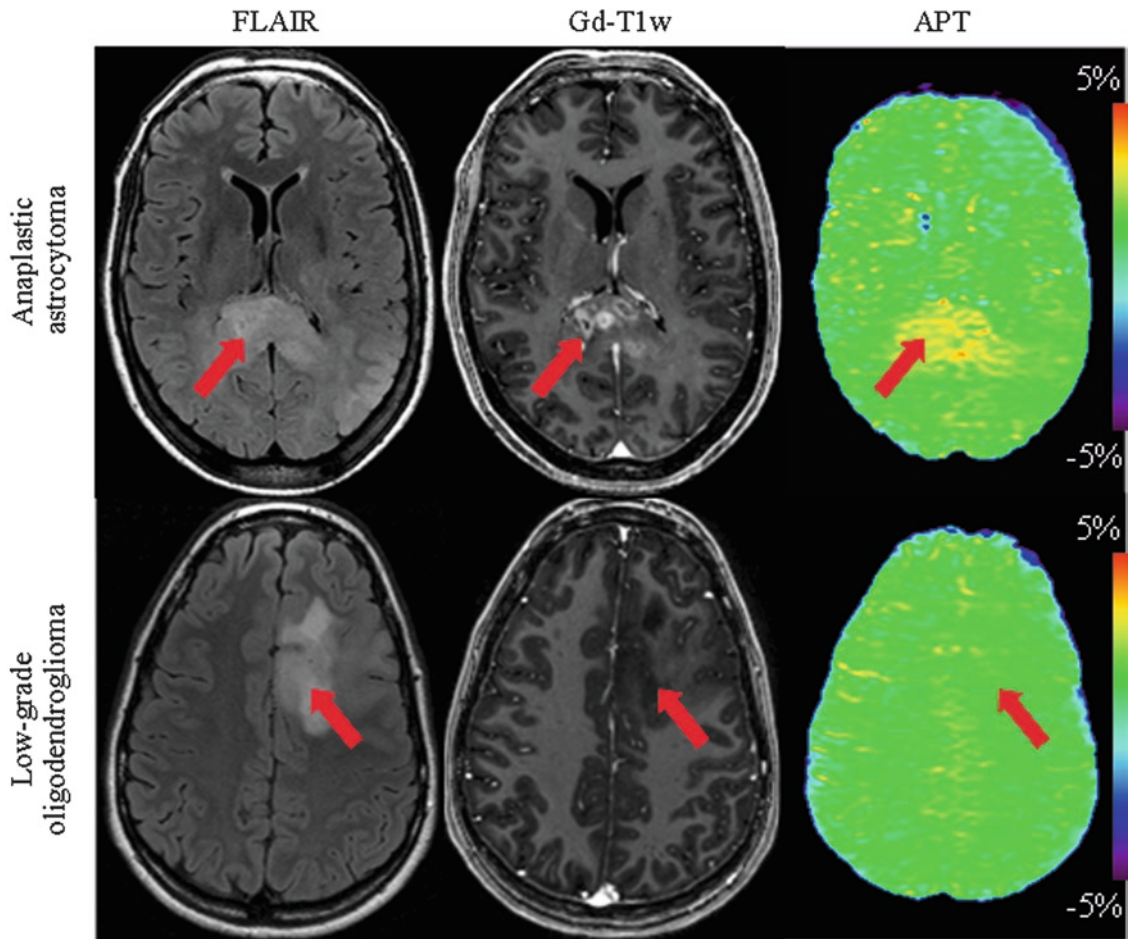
Top row:* MR images of a patient with an anaplastic astrocytoma. It can be seen clearly that hyperintensity is present on APT and Gd-T<sub>1</sub>w. The hyperintense APT area is smaller, or comparable in size to the lesion identified on FLAIR, but larger than that on the Gd-T<sub>1</sub>w image. *Lower row:* MR images of a patient with a low-grade oligodendroglioma. Despite clear abnormalities on FLAIR, there is no visible signal enhancement in tumor on either the Gd-T<sub>1</sub>w or APT images. Data were acquired on a 3T Philips MRI scanner with a six-channel phased-array coil for reception. A six-offset APT data acquisition approach (Zhou et al. 2008) was used to correct for the artifacts induced by B<sub>0</sub>-inhomogeneity. The experimental parameters used were: TR = 3 s; TE = 30 ms; matrix = 128 × 128; FOV = 230 × 230 mm<sup>2</sup>; single-slice; slice thickness = 5 mm; RF saturation time = 500 ms; and saturation power = 4 μT. The total scan time was about 4.5 min (Reprinted from Zhou et al. 2008. With permission from Wiley-Liss, Inc.)
